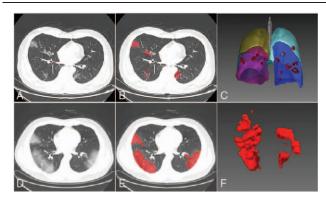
Pulmonary and pneumonia of different layers under CT. A and D are different scan layers, B and E correspond to the lesion areas of A and D at the same layer, marked with red; C is the 3D model of the 2 lungs, the total volume represents the value of Vin, and the red parts represent the focus of pneumonia; F displays the 3D model of the pneumonia lesions. The computer software can calculate PV and PVR according to C and F. PV = pneumonia volume under CT scan, PVR = pneumonia volume ratio, Vin = full inspiratory volume.
